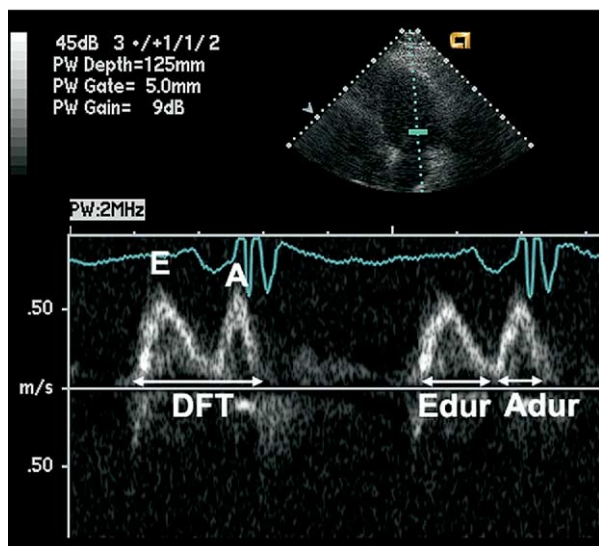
Pulsed wave Doppler mitral inflow velocity and measurements of left ventricular filling. *A*, Atrial filling velocity; *A dur*, atrial filling duration; *DFT*, diastolic filling time; *E*, early filling velocity; *E dur*, early filling duration.
